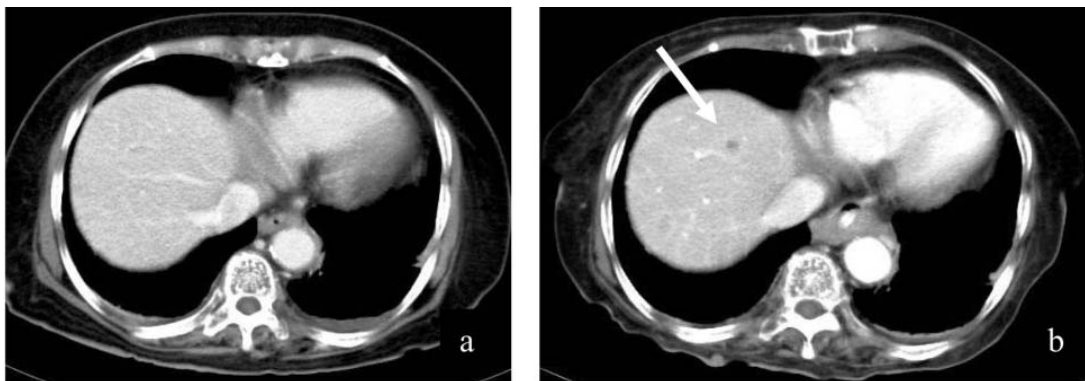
Contrast-enhanced CT scan of a 71-year-old male with advanced GIST, pretreatment scan showed no space-occupying lesion (a). Newly developed cystic lesion (arrow) in superomedial segment of left hepatic lobe was visualized in post treatment image (b).
